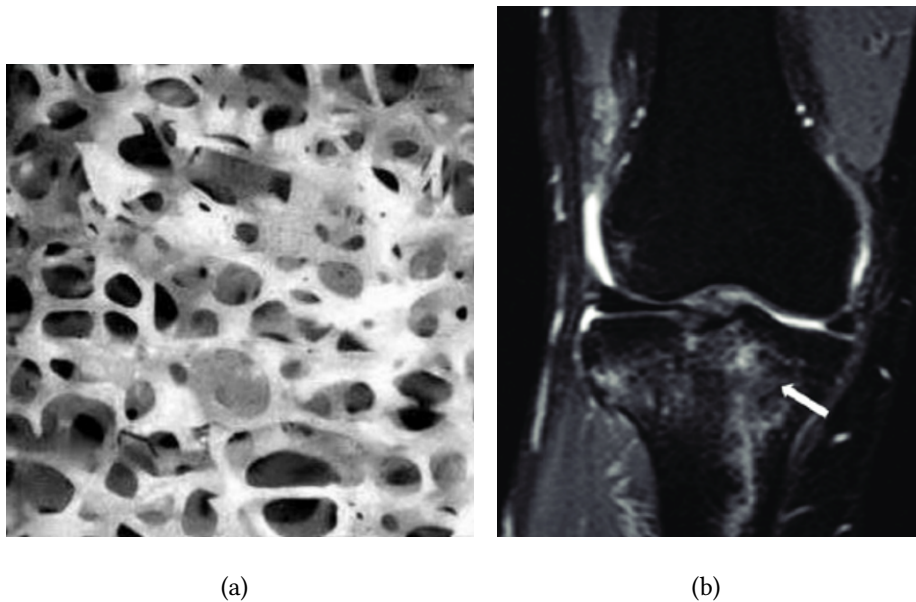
a) Bone trabeculae. b) PD MRI with a marrow oedema. *Source: a)Tissue Engineering, University of Malaga, Andrades,J.A. B)Chemical shift imaging: An indispensable tool in diagnosing musculoskeletal pathology's (May 2021, Vandana,J.) [18]*
